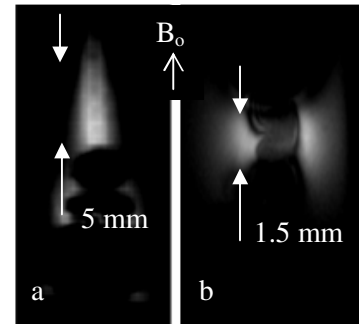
Full-width-half-max excitation slice width of modified loopless antenna (a) and multi-turn loop (b) as measured by projection MRI.
